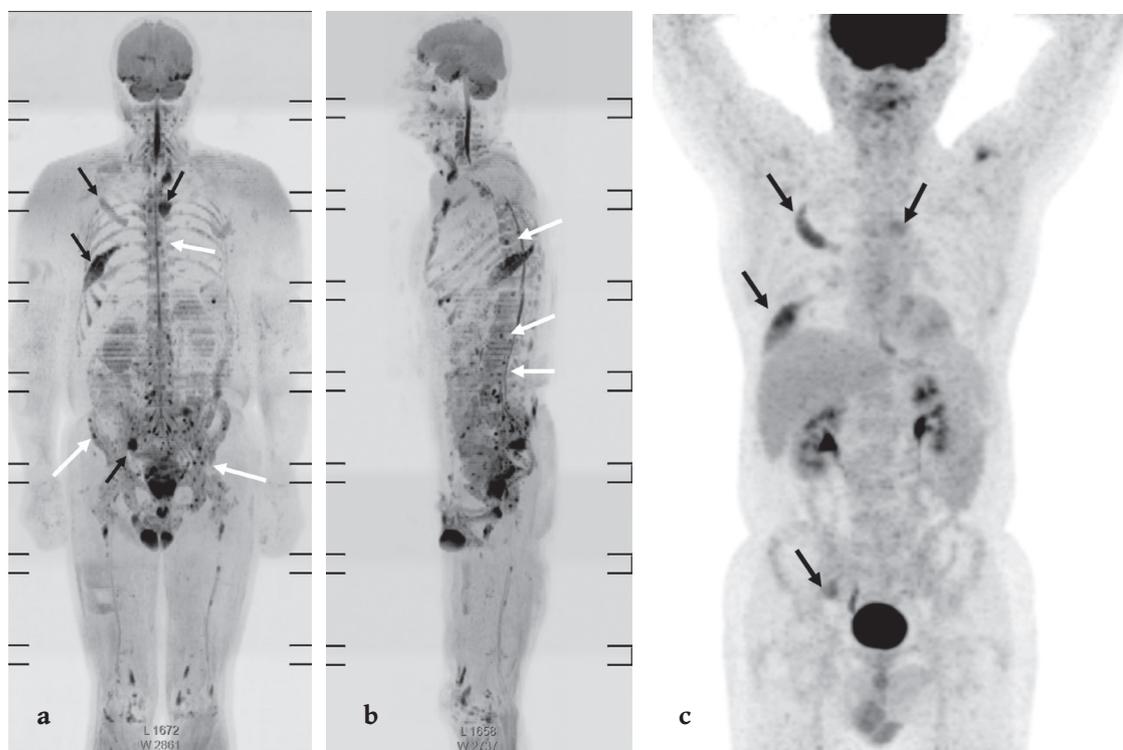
67-year-old man with newly diagnosed multiple myeloma. Whole body DWI maximum intensity projection (b value 900 s/mm², inverted greyscale) coronal (a) and sagittal (b) images. 18F FDG/PET-CT coronal image (c). Focal lesions (black arrows) are shown on both studies. On WBDWI multiple additional smaller foci of disease are also seen in the spine and pelvis (white arrows).
